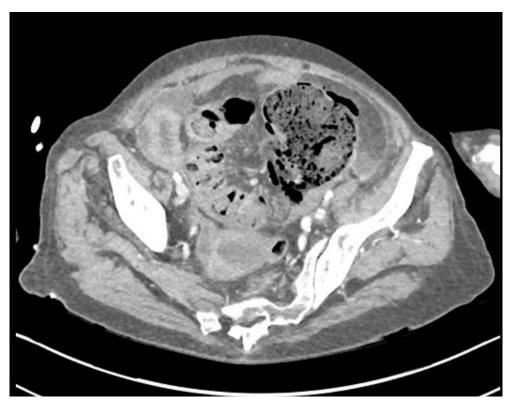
Abdominal CT scan who shown the stercoral perforation of the left colon.
